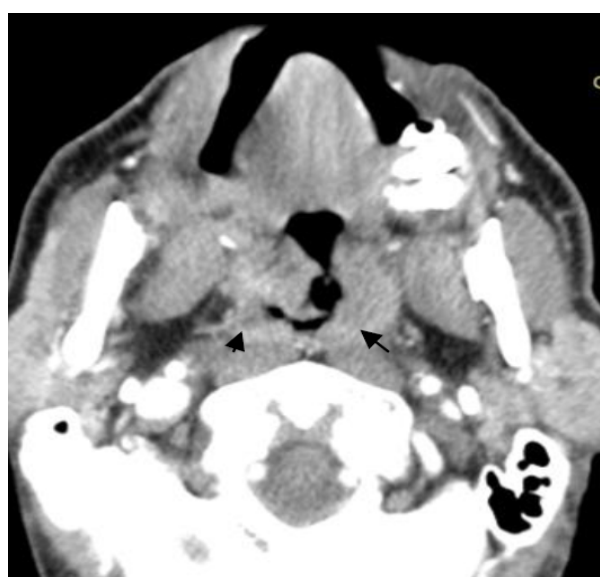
Axial contrast-enhanced CT scan through the oropharynx demonstrates a bilateral enlargement of the soft palate and posterior tonsillar pillars (small black arrows).
